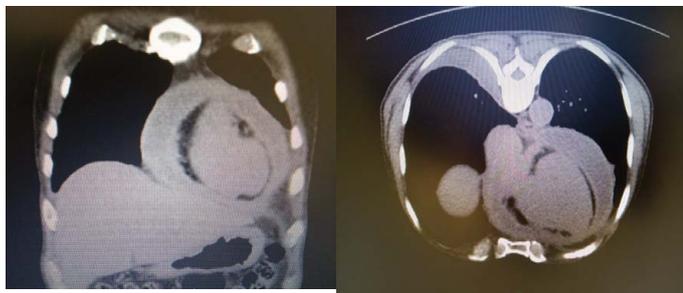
Plain CT scan of chest showing moderate pericardial effusion with maximum thickness 26 mm and associated thickening of parietal pericardium.
